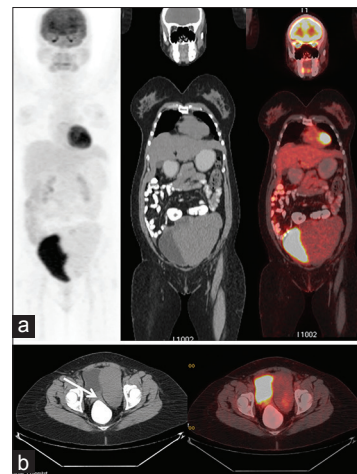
(a) Maximum intensity projection (MIP) and coronal positron emission tomography/computed tomography (PET/CT) images of pelvis showing a large, non-fluorodeoxyglucose (FDG), avid, uniform-density, solid mass isodense to muscle. (b) Axial sections showing continuity of the mass with anterior cervical wall (arrow)
